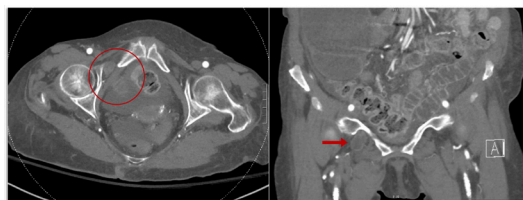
CT angiogram showing a right-sided obturator hernia in axial (red circle, left) and coronal (red arrow, right) views.
